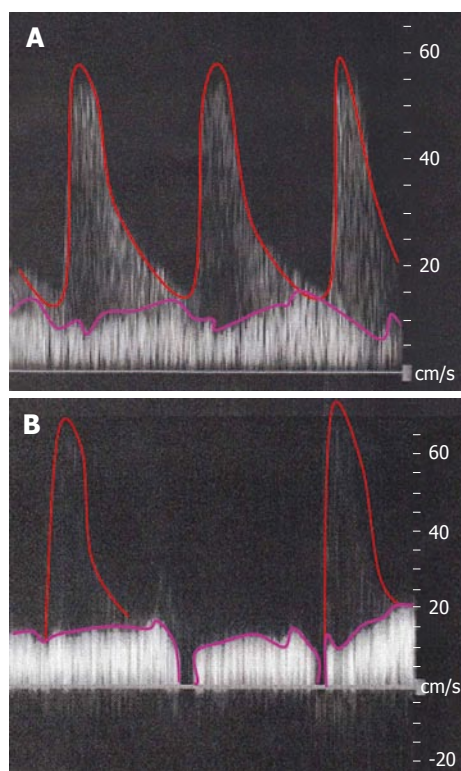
Decreased portal venous flow due to unstable systemic hyperdynamic state (A and B). Even a subtle instability of systemic hyperdynamic state (i.e., an imbalance of CO and BV in the lower TPR) results in a decreased PVF. During the PVF measurement by Doppler ultrasound, HA waveform (Red line) blends into the background of a decreased PVF (purple lines). BV: Blood volume; CO: Cardiac output; HA: Hepatic artery; PVF: Portal venous flow; TPR: Total peripheral resistance.
